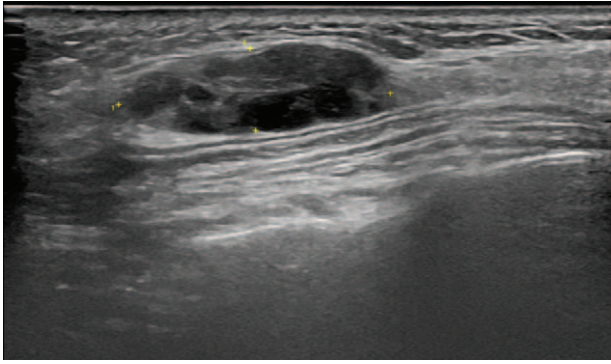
Ultrasonography revealed a lobulated hypoechoic mass measuring 2.5×0.8 cm with increased vascularity in the subcutaneous layer of the left cheek.
